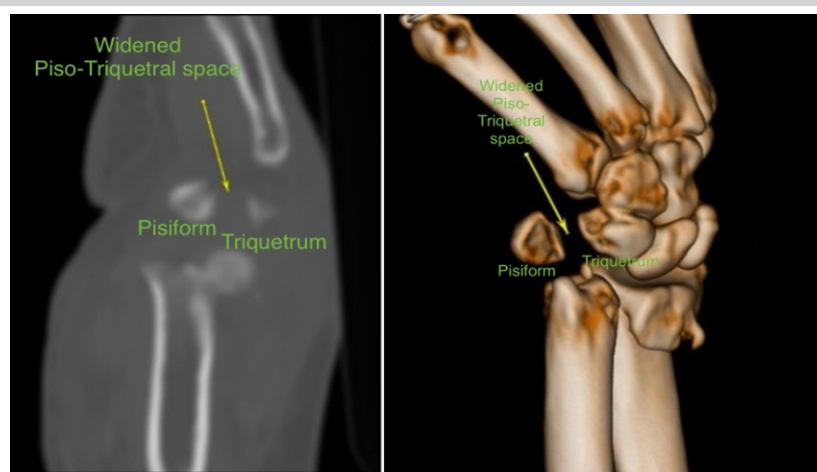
(a and b) Non-contrast computed tomography wrist (sagittal sections) with 3D reconstruction demonstrating volar migration of the pisiform relative to the triquetrum (arrows). Note the complete loss of pisotriquetral articular congruity and marked widening of the joint space, consistent with a volar dislocation pattern.
